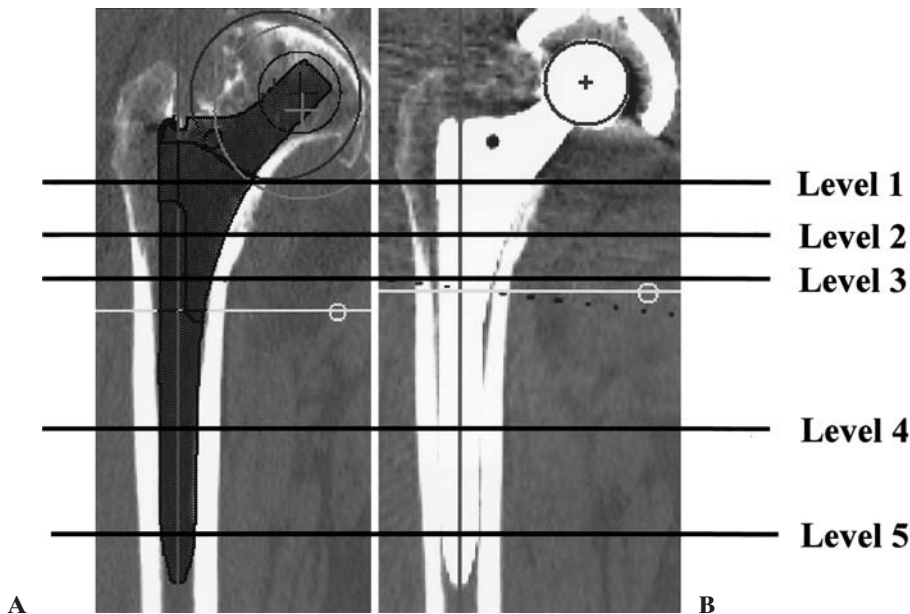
The five lines indicate levels 1 to 5. A The symmetry plane of the femoral component from preoperative planning. B The symmetry plane of the femoral component reconstructed from postoperative CT data
